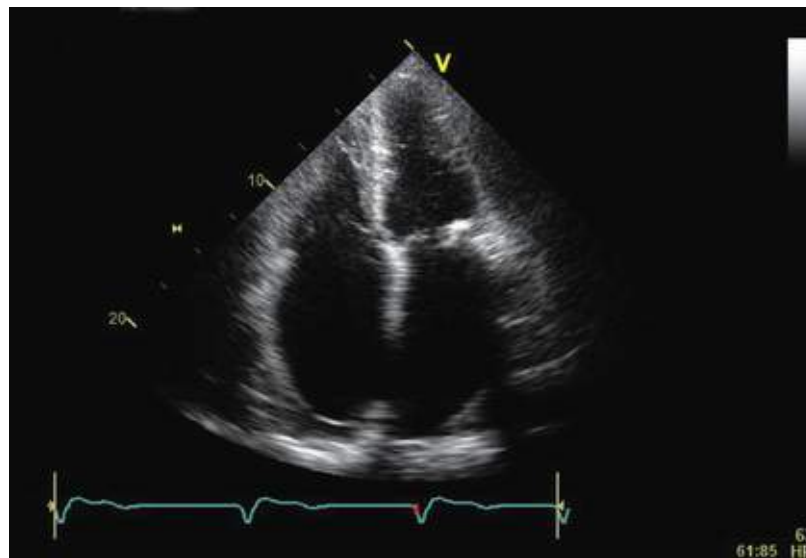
Echocardiogram showing restrictive cardiomyopathy. An apical four-chamber view is shown in an 80-year-old man with long-standing RCM. The LV ejection fraction was normal, with evidence of severe diastolic dysfunction on echocardiography and cardiac catheterization. Note the massive biatrial enlargement and normal LV wall thickness.
